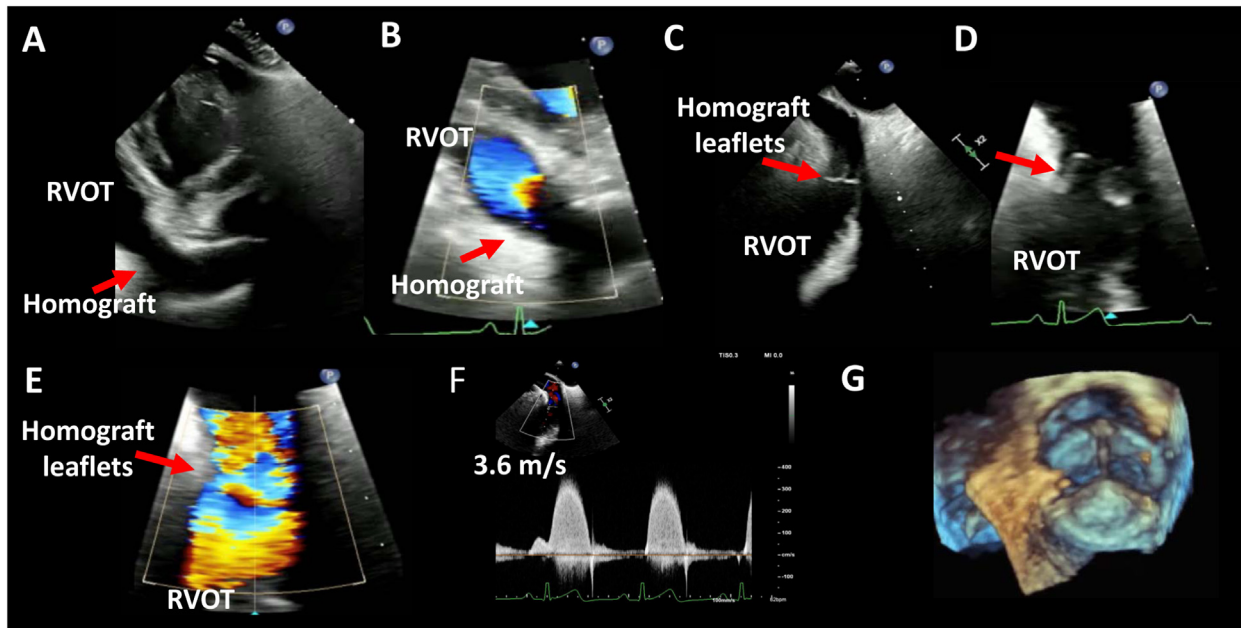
Transesophageal echocardiographic image from a deep transgastric window at about 60°, in a patient who underwent a Ross procedure for infective endocarditis, demonstrating the cardiac structures surrounding the pulmonary homograft (A). The zoomed deep transgastric images with color Doppler demonstrate flow acceleration in the homograft (B). A high esophageal view at about 130° provides a clear view of the homograft leaflets (red arrows, C), with restricted motion (D) and flow acceleration across the leaflets by color Doppler (E). CW Doppler (F) measures peak and mean systolic gradients of 52 and 30 mm Hg, respectively. The patient underwent surgical replacement of the pulmonary valve with a Sorin prosthesis; a 3D image of the valve is shown (G).
